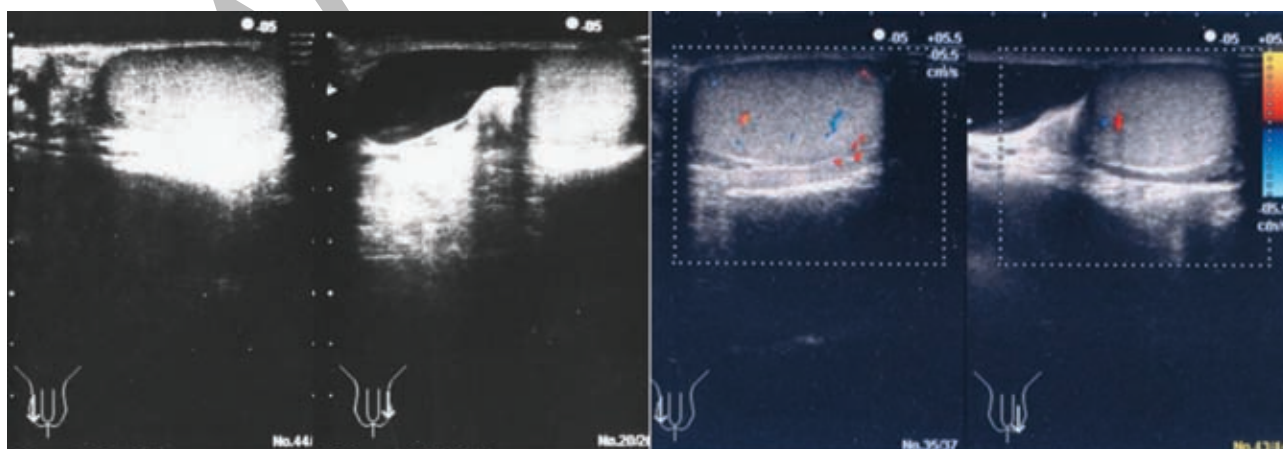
Left, Scrotal ultrasonography demonstrates a cystic lesion adjacent to the left testicle. Right, Doppler ultrasonography suggests slight decrease in the blood flow of the left testis compared with the right one.
